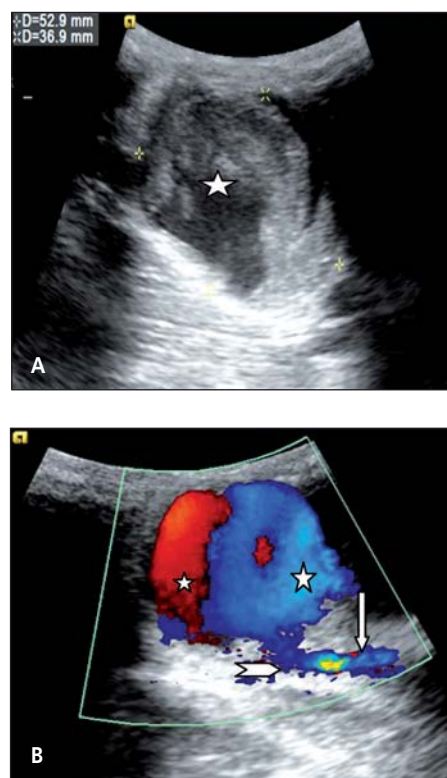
(A) Ultrasound showing a pulsating juxta-arterial heterogeneous mass with hypo-echoic eccentric area (star), (B) color Doppler ultrasound showing (stars) swirling color flow (yin, yang sign) in the mass (PSA) separated from the brachial artery (arrow) with color flow within the tract (chevron) between the artery and the mass.
